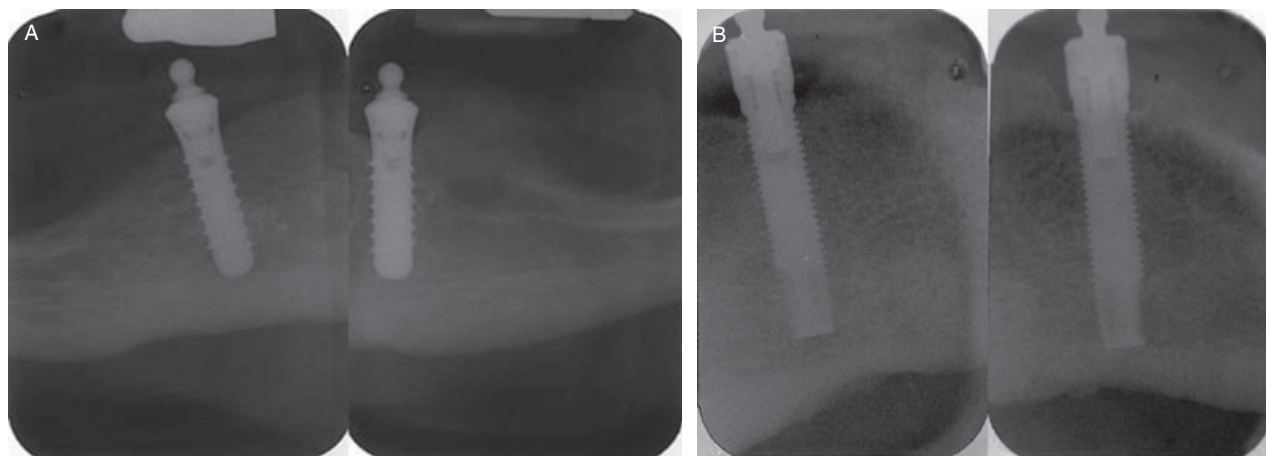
A, 5-year periapical view of a patient rehabilitated with Straumann implants. B, 5-year periapical view of a patient rehabilitated with Brånemark implants.
